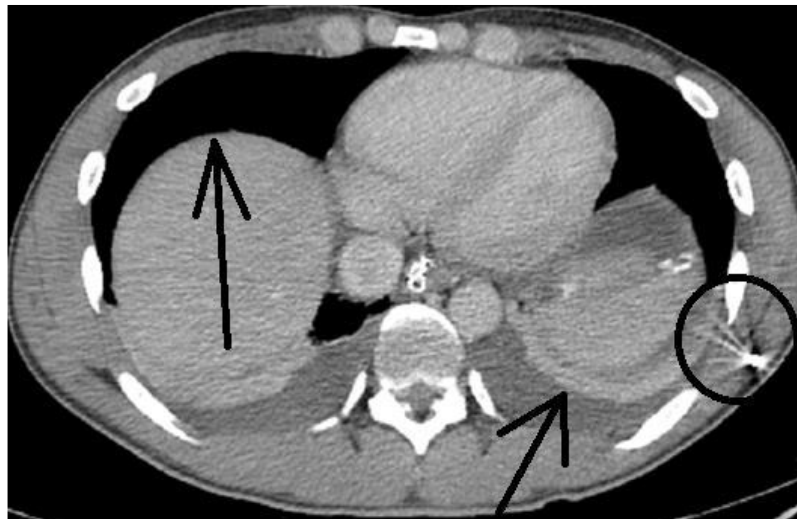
CT scan of abdominal organs, axial projection. Free gas (upper arrow) and fluid (lower arrow) in the abdomen, foreign body (bullet) in the soft tissues of the abdomen on the left (circle).
